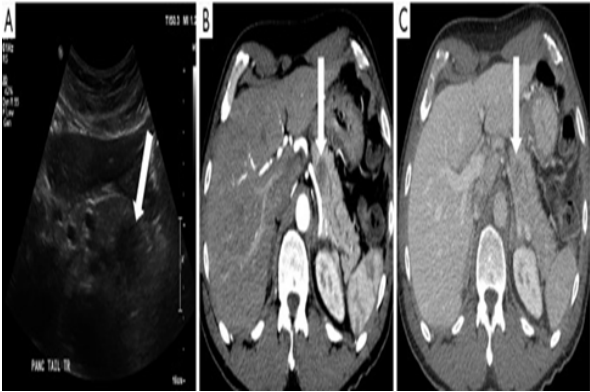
(A) Ultrasound and (B) MDCT outcome of pancreatic body and duct.
